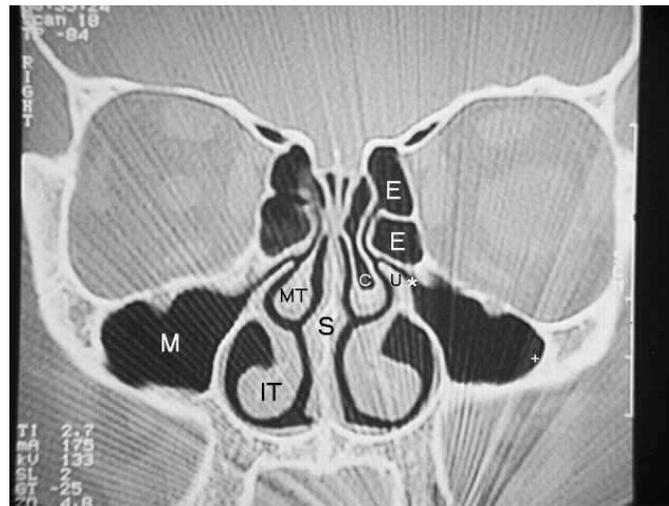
CT-Scan of sinuses showing normal sinuses
